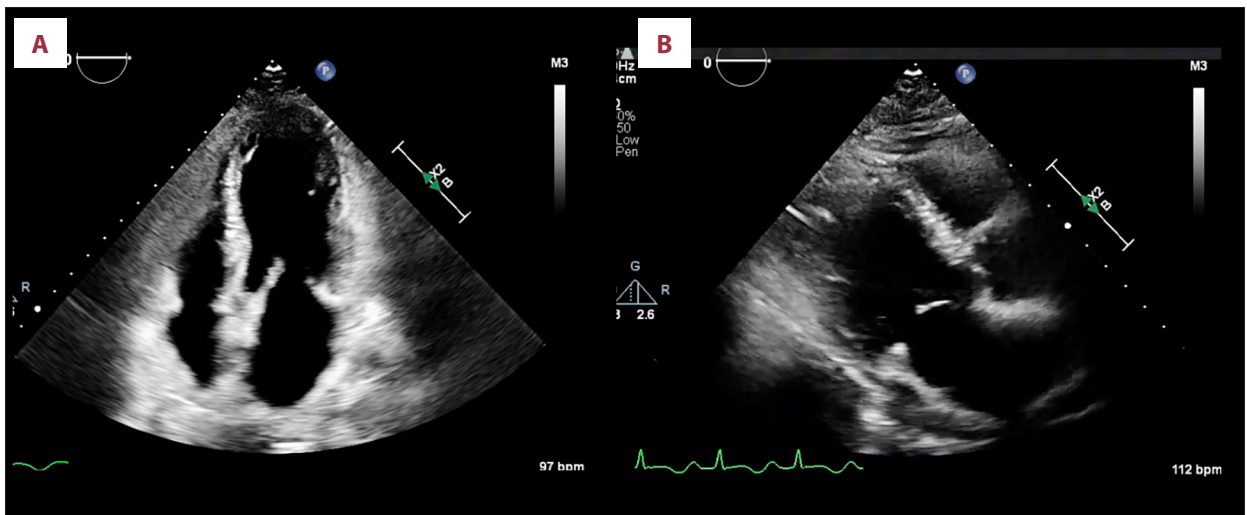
(A) Prior echocardiogram, 4-chamber view. Echocardiogram from the prior admission showing apical hypokinesis with preserved basal function, consistent with classic apical takotsubo cardiomyopathy. (B) Prior echocardiogram, parasternal long-axis view. Parasternal long-axis view from the previous episode demonstrating apical dysfunction with preserved basal contractility.
